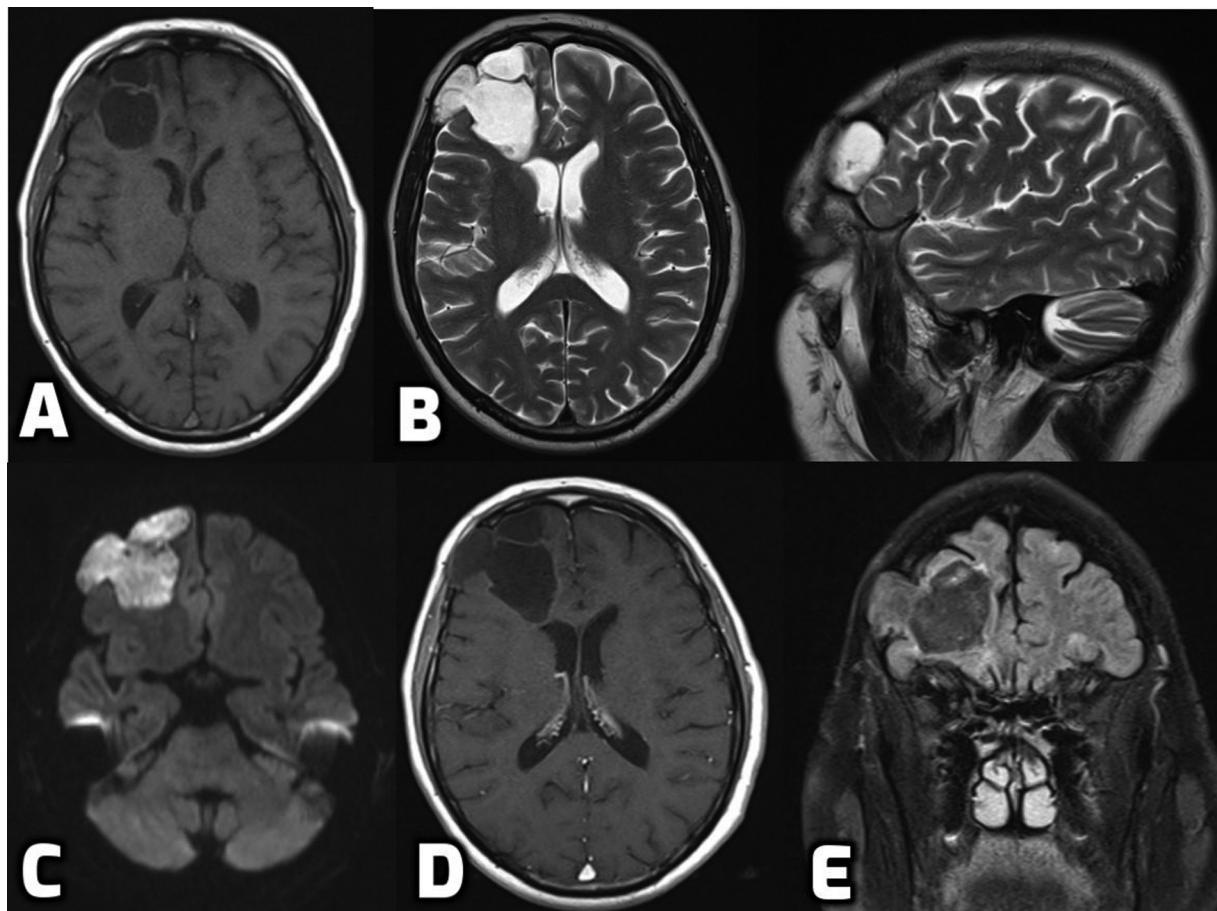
(A) T1-weighted axial magnetic resonance imaging (MRI) of the brain from 2020 showing the marginally increased hypointense cyst. (B) T2-weighted axial and sagittal MRI of the brain showing the homogenous multiseptated cyst with involvement of the frontal bone. (C) Diffusion-weighted MRI of the brain showing marked restriction within the lesion. (D) T1-weighted postcontrast axial MRI of the brain showing the absence of enhancement within the lesion. (E) Fluid-attenuated inversion recovery (FLAIR) coronal MRI of the brain denoting the intracerebral and extra-axial extension with no perilesional edema.
